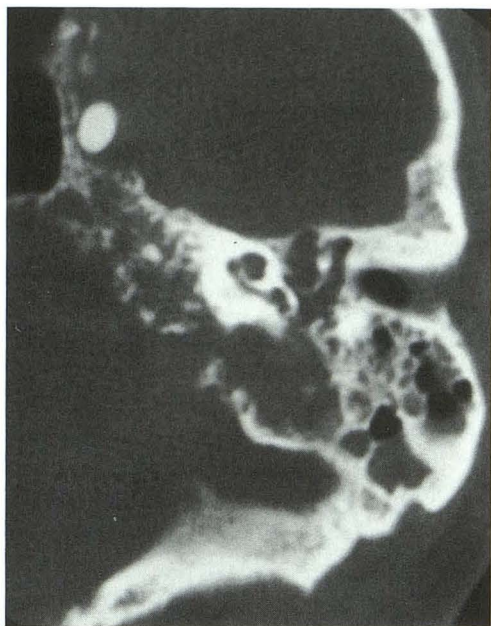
Adenocarcinoma of temporal bone. CT shows bone destruction of margins of the posterior fossa, jugular bulb, carotid canal, middle ear, and petrous apex. A contrast-filled balloon is in the cavernous carotid (second balloon in the high cervical carotid, not shown).
